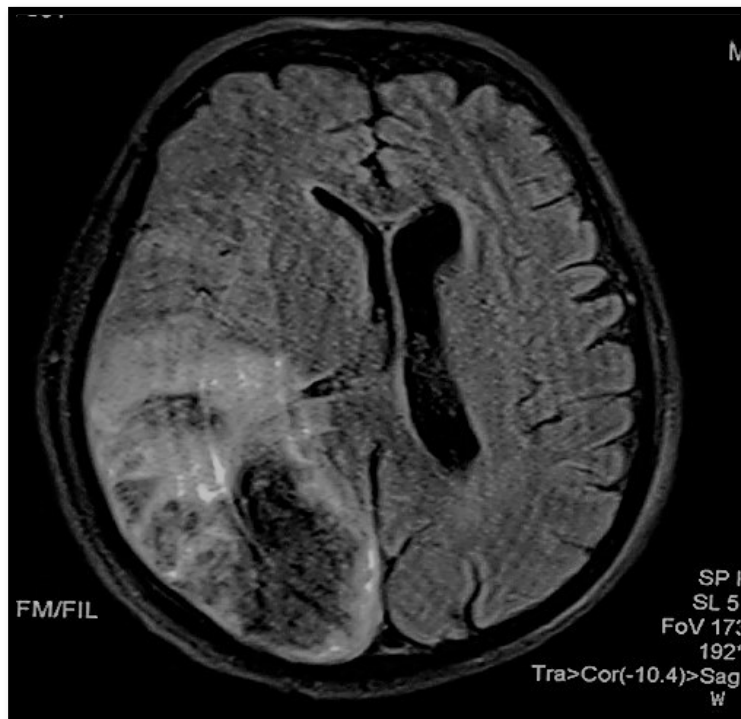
Infarct in Right temporo-parietal and occipital area (MRI)
